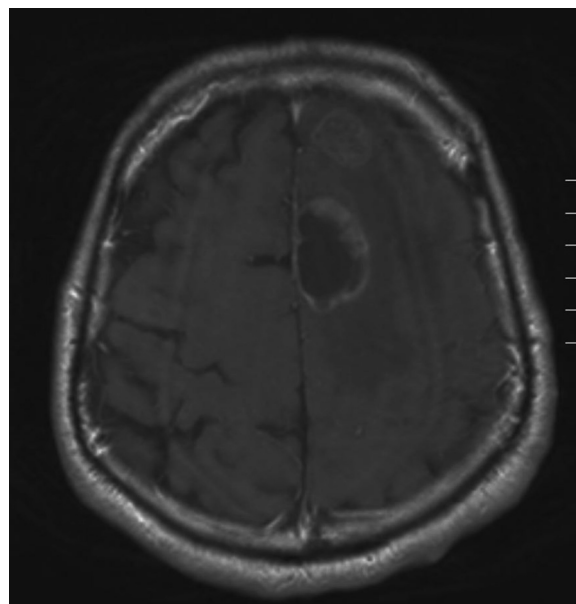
Magnetic resonance imaging of the brain (T1 weighted images post gadolinium contrast) demonstrating two cerebral metastases. The adenocarcinoma metastasis is the solid anterior lesion and the squamous metastasis the posterior cystic lesion.
